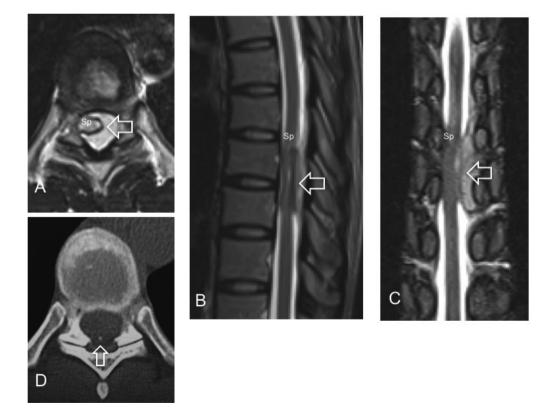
Axial (A), sagittal (B), and coronal (C) T2-weighted preoperative MRI of the thoracic spine showed an iso-hyper signal intense mass (leftwards arrow) surrounding the dura mater. Preoperative CT (D) shows partial calcification (upwards arrow). Sp: Spinal cord
